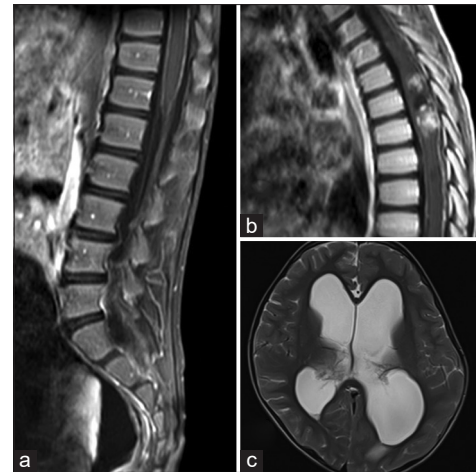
(a) Leptomeningeal contrast enhancement at the conus. (b) Sagittal contrast-enhanced T1-weighted image shows intramedullary lesion at T5–7 level. (c) T2 fluid-attenuated inversion recovery axial image shows hydrocephalus
